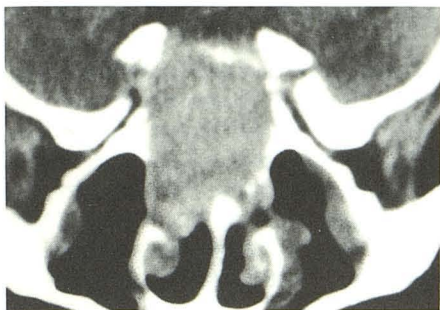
Patient 3. Coronal postcontrast CT scan shows enhancing destructive lesion of central skull base, sphenoid sinus, and posterior nasal vault. This is a representative scan of the cases of central skull-base metastasis. The enhancement can be appreciated by comparison to the attenuation of the brain.
